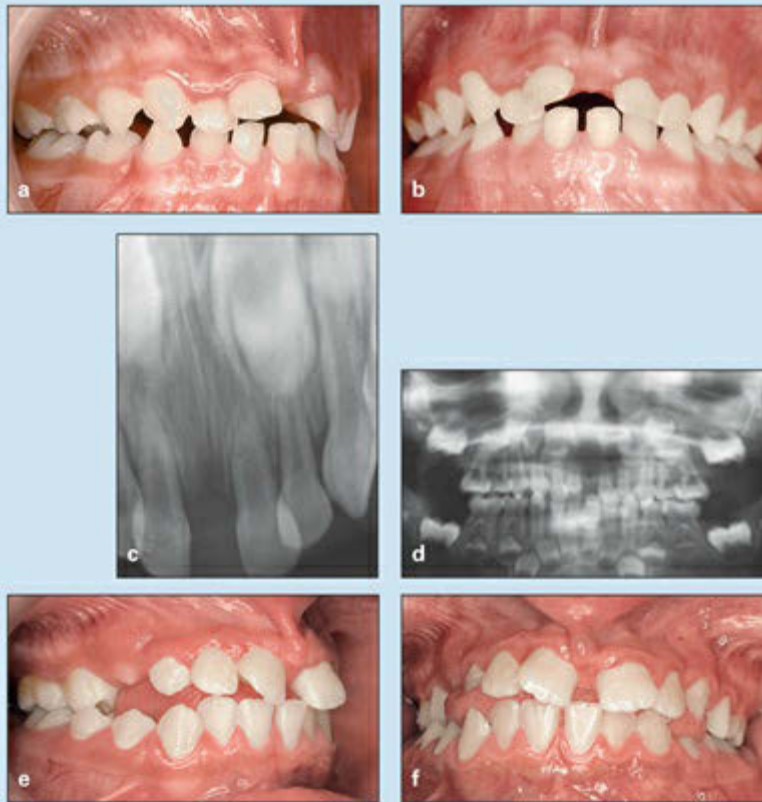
Treatment of a girl with a severe hereditary diastema, resulting from a strong and low abnormal frenum attachment in the primary dentition, and displaced incisors. (a to c) Occlusion at 5 years. Her parents were advised to return for evaluation when all the child's incisors had erupted. (d) Panoramic radiograph of the primary dentition. (e and f) Occlusion in the late mixed dentition, showing significant frenum attachment, a severe V-shaped diastema, and incisor displacement.
